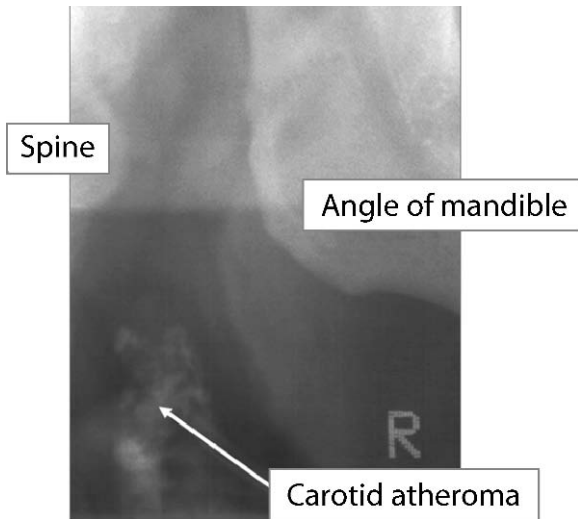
Detail from panoramic radiograph
